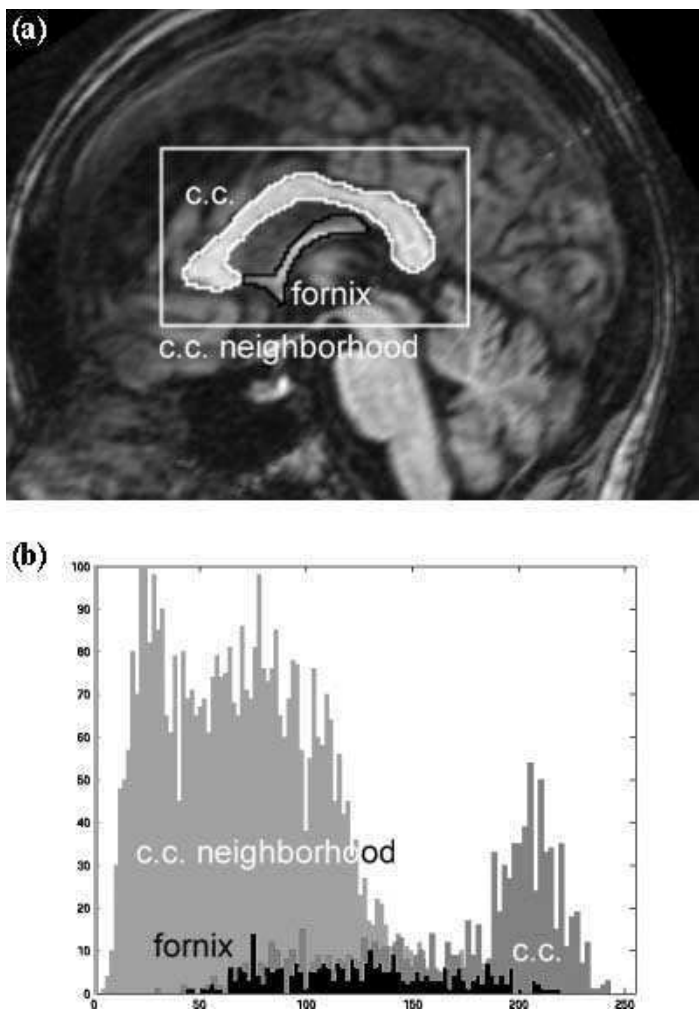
The corpus callosum (c.c) and its neighbors in a T_1 -weighted MRI section (a) and their associated intensity distributions (b).
